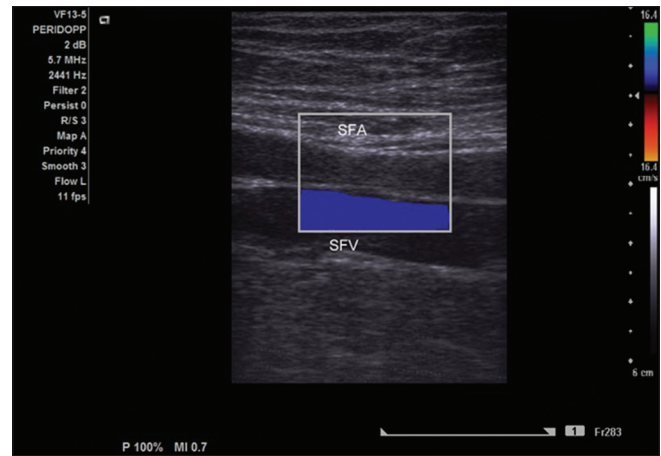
Longitudinal color Doppler image of chronic thrombosis of superficial femoral artery with thickened walls
